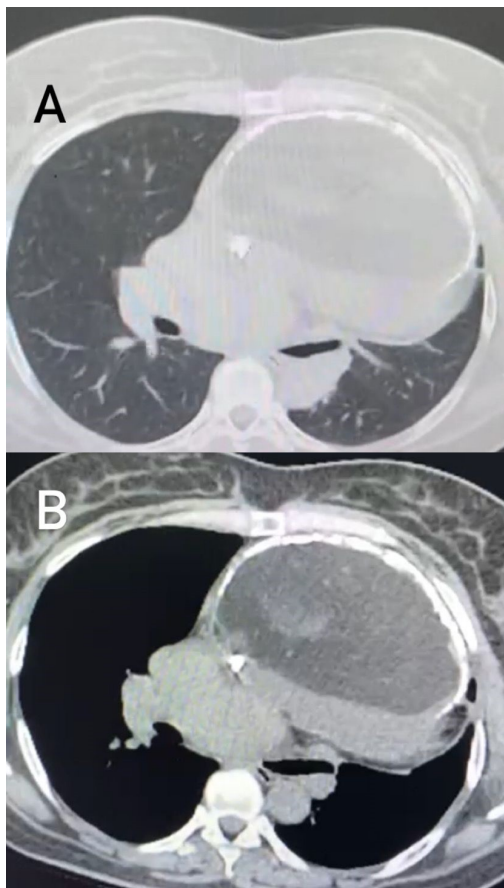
A- Presentation of the anterior mediastinal tumor in its largest diameter on computed tomography of the chest. B- Same cut in mediastinum
